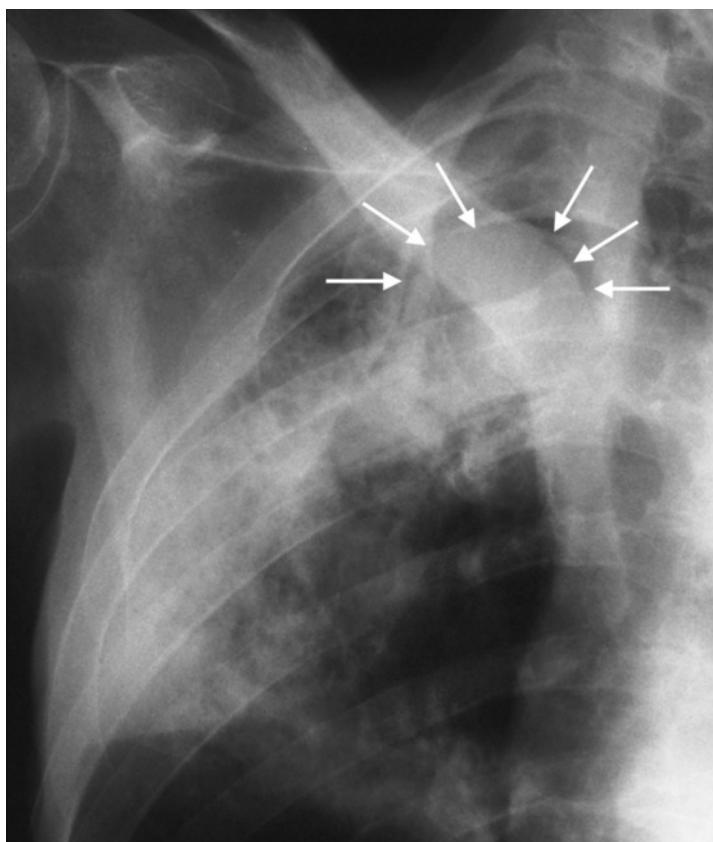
“Fool’s cap bell” in aspergilloma (detail). The patient is a 79-year-old man with severe COPD and emphysema, now presenting with dyspnea, fever, and productive cough. In addition to extensive bronchopneumonia of the right upper lobe, the radiograph also demonstrates a mass 4 cm in diameter with an apical air crescent (white arrows).
